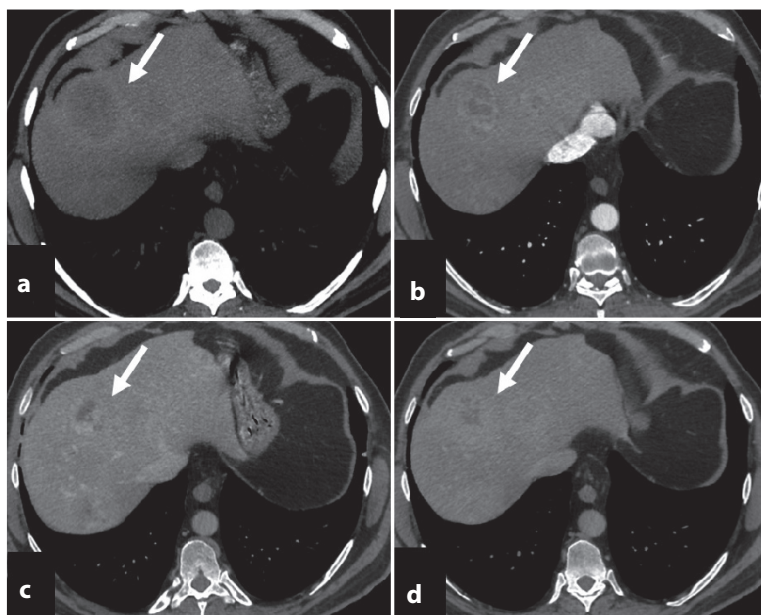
Liver metastasis from NET of the ileum in a 54-year-old man. (a) Axial unenhanced CT shows a hypodense lesion (*arrow*) in segment VIII (50 mm). (b) Axial early arterial phase contrast-enhanced CT shows hypervascular ring enhancement (*arrow*). The portal (c) and delayed phase (d) show a progressive hemangioma-like enhancement (*arrows*)
